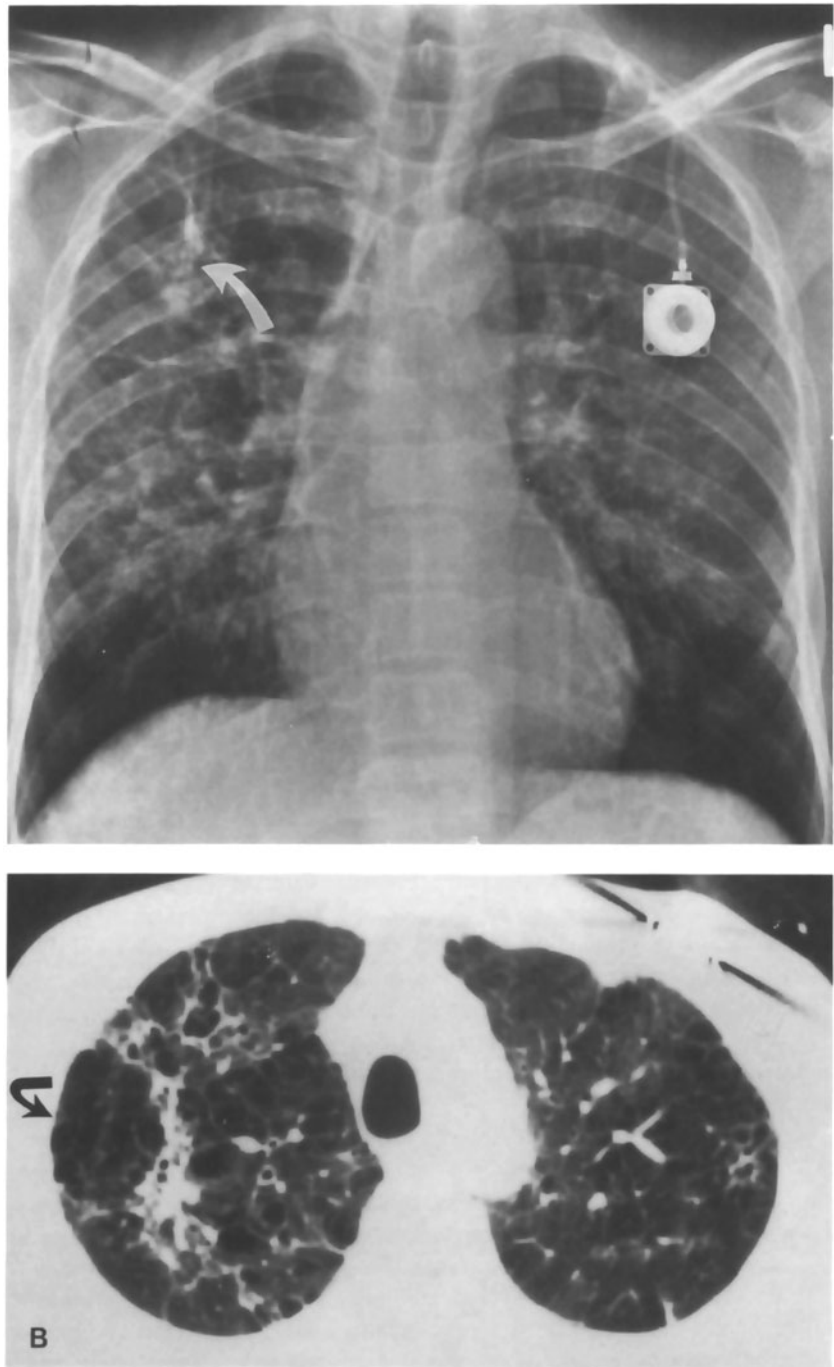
Cystic apical *Pneumocystis carinii* pneumonia. (A) Cystic lung regions of *Pneumocystis* pneumonia are most evident in the right apex of an HIV-positive patient treated with aerosolized pentamidine. (B) A CT scan confirms cystic lesions with well-formed walls, characteristic of post-aerosolized pentamidine *Pneumocystis* pneumonia, and unlike bullous emphysema.
